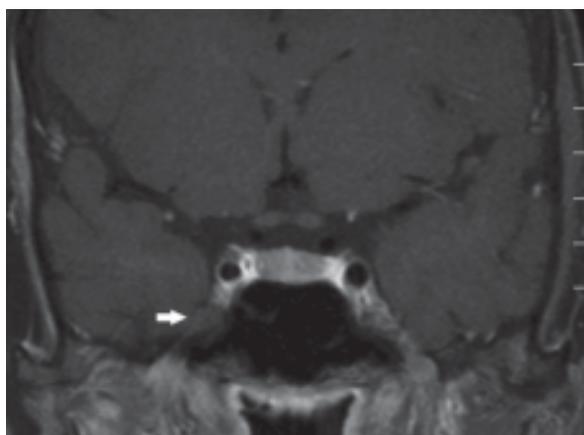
The chloroma of mandibular branch (V3) of trigeminal nerve. Coronal contrast-enhanced T1-weighted MR image shows altered signal intensity of Meckel's cave (arrow) and right mandibular nerve in continuation throughout foramen ovale caused by chloroma. Trigeminal nerve was only site of involvement in this patient who complained of neuralgia.
